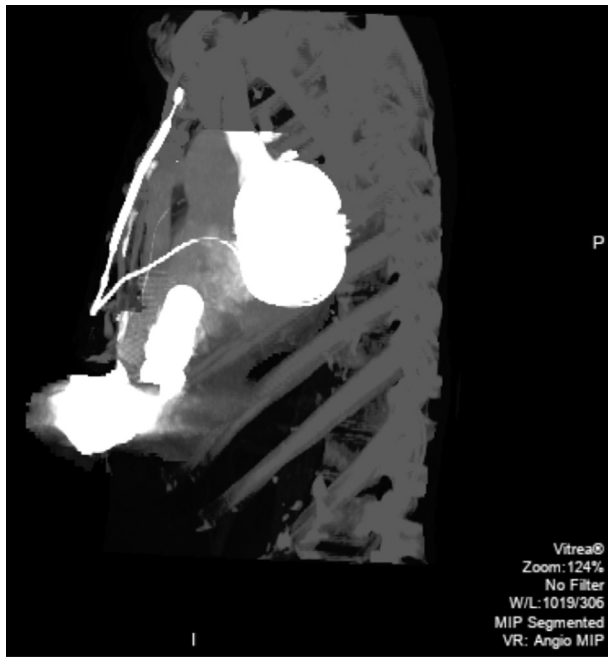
Lateral computed tomography showing implanted subcutaneous implantable cardioverter-defibrillator in relation to HeartMate II (Abbott, North Chicago, IL) left ventricular assist device.
